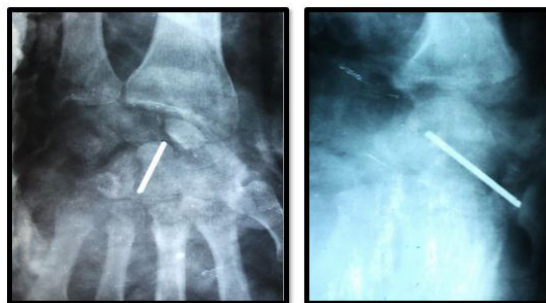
Left wrist post- operative X-Ray the capitate head was replaced and nailed and no ostosynthesis for the scaphoid.
